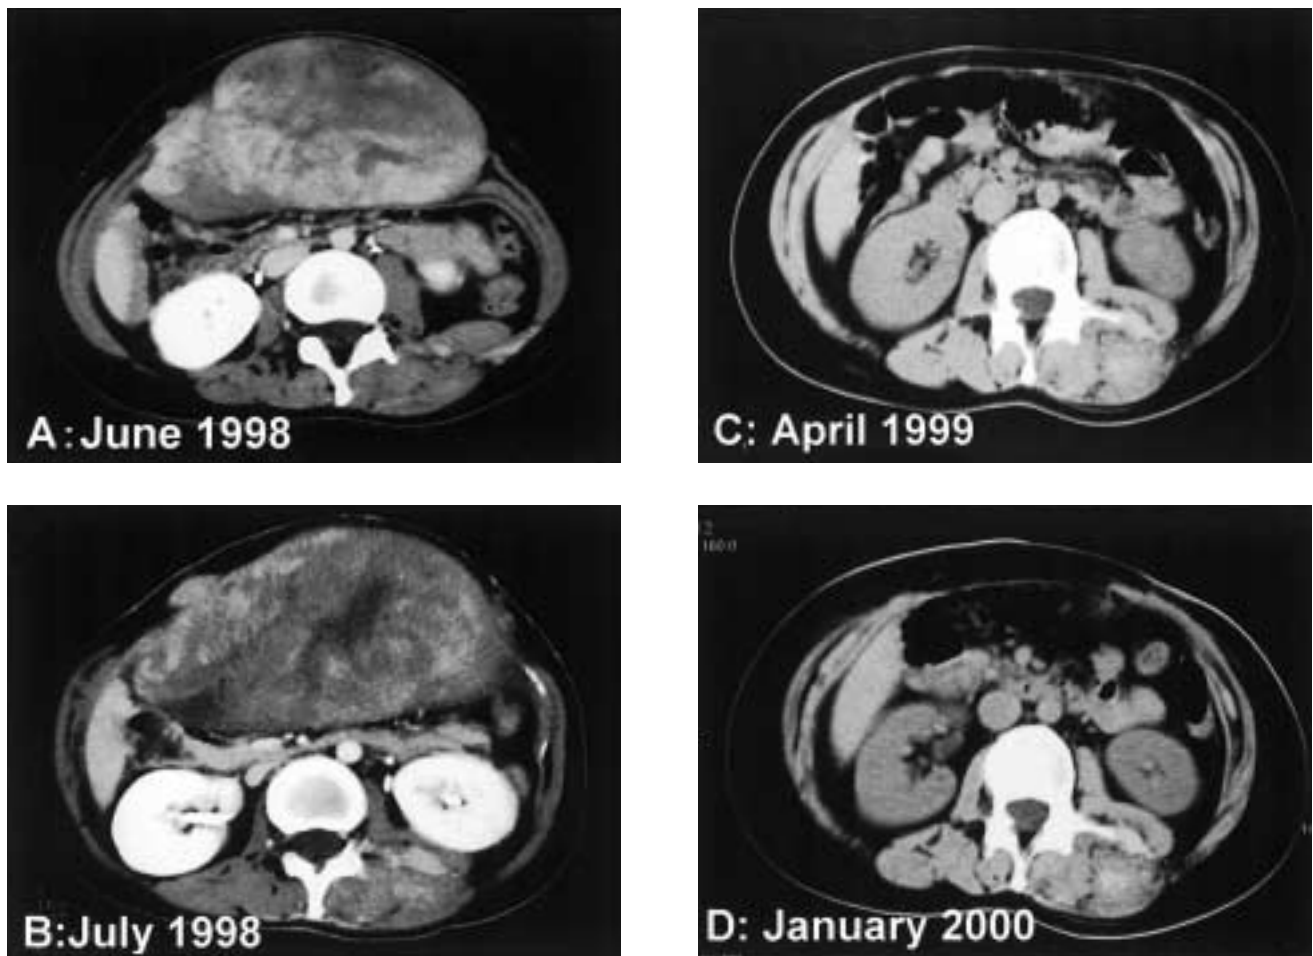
Computed tomography images of a desmoid tumor. The tumor was 25 × 23 cm in diameter at the first recurrence (A) and 28 × 35 cm at the second recurrence 6 months later (B). The doubling time was estimated to be 122 days. After the resection and docetaxel treatment, no recurrent tumor was detected for 2 years (C) and (D).
